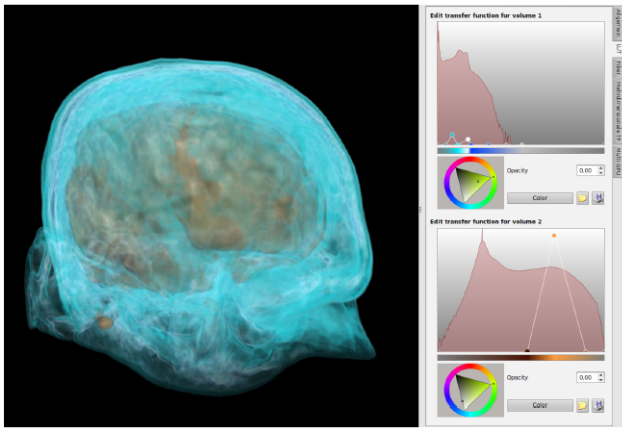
(Color online) Multi-modal ray casting visualization of MRI (blue) and PET (ocher) data sets with two different 1D transfer functions
